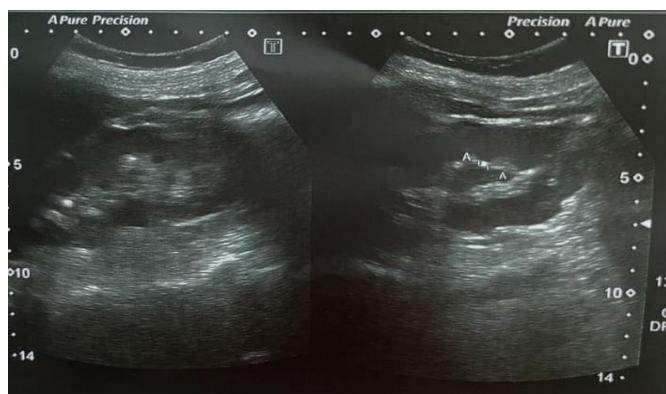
Transabdominal Ultrasound Showing Multiple Renal Calculi in the Right Kidney (Largest Measuring 3.9 mm)
